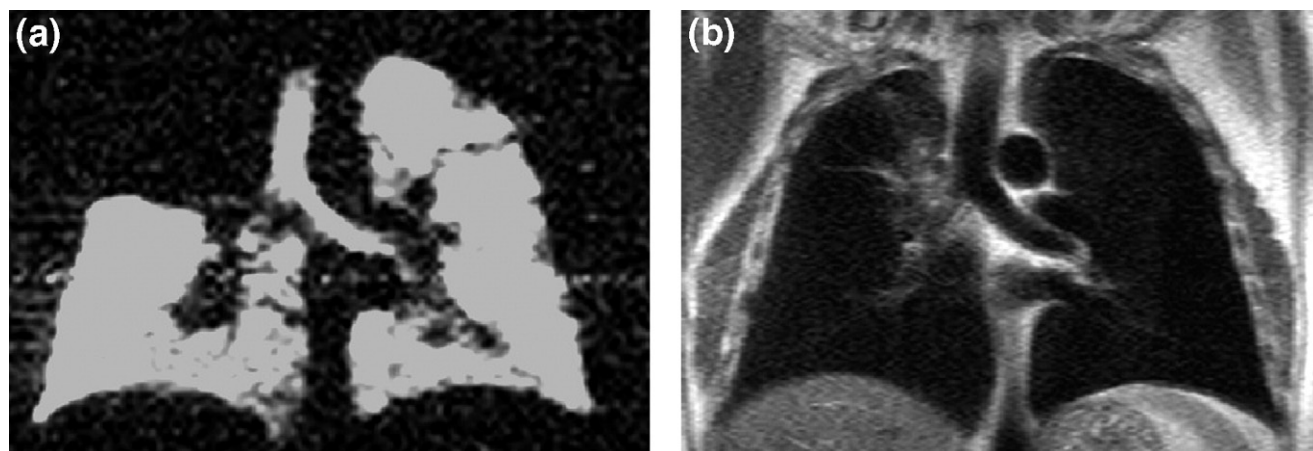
(a) Hyperpolarized <sup>3</sup>He magnetic resonance image exhibiting a complete ventilation obstruction for a patient with a tumor in the upper right lobe. (b) Corresponding <sup>1</sup>H magnetic resonance image.
